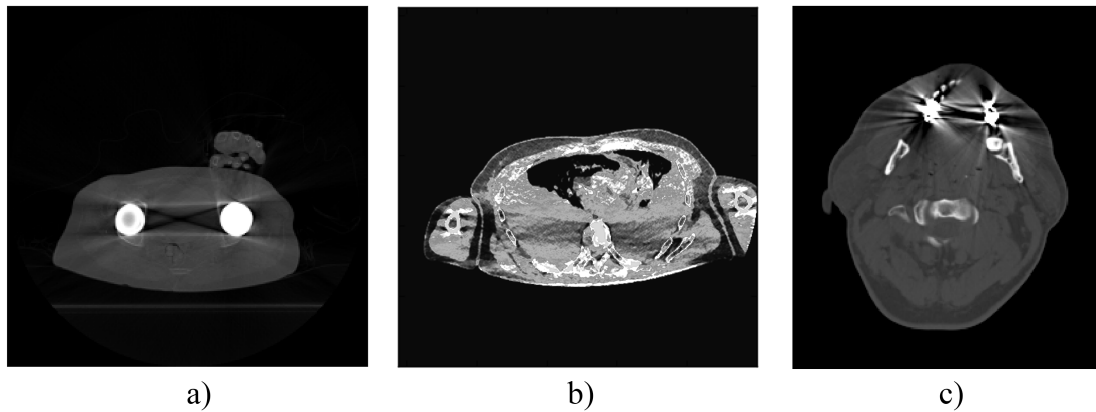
Examples of coupling artefacts found in the CT database. a) Between bilateral hip replacement. b) Between the arms, affecting the HU values of the tissues in the thorax. c) Between metal fillings in the teeth.
